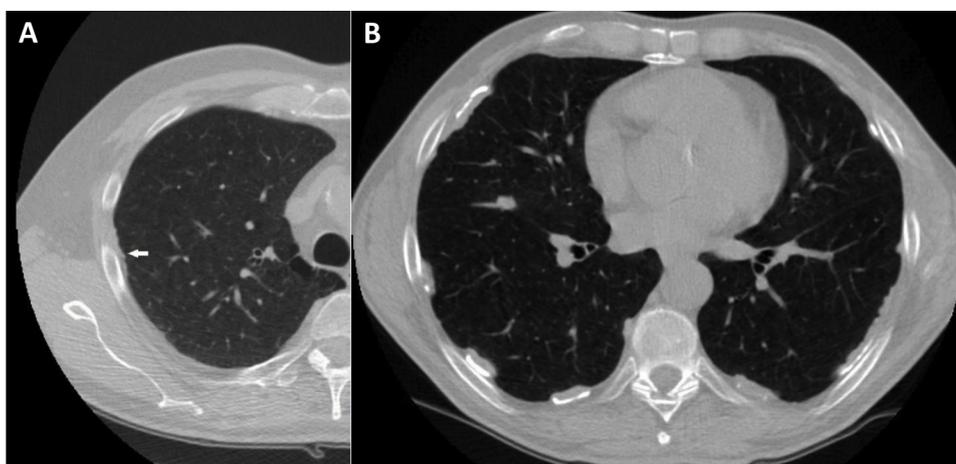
Low-dose CT scan findings.
